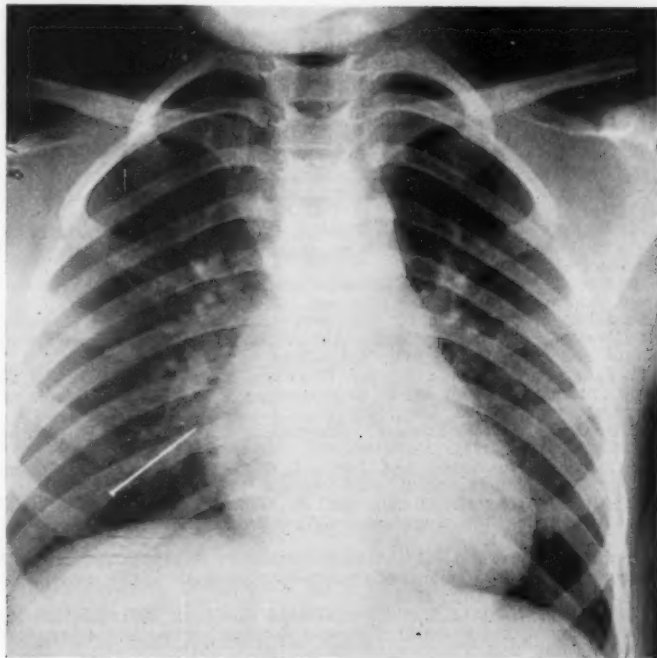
Postero-anterior roentgenogram. Straight pin in the right lower lobe.
